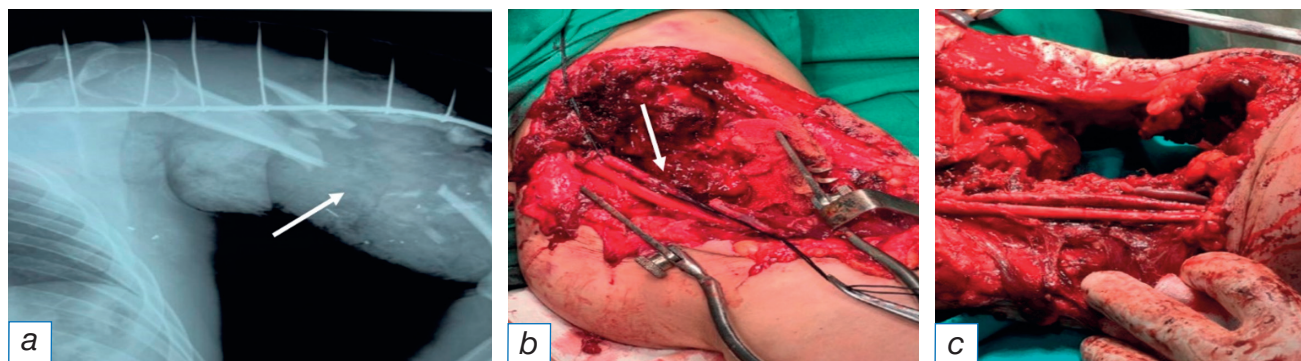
The vascular defect was replaced with the autovenous transplant. a — radiography of the left shoulder (destruction of the humeral bone shown by the arrow); b — the defect of the brachial artery in the left shoulder (arrow); c — autovenous prosthetic replacement of the left brachial artery.
